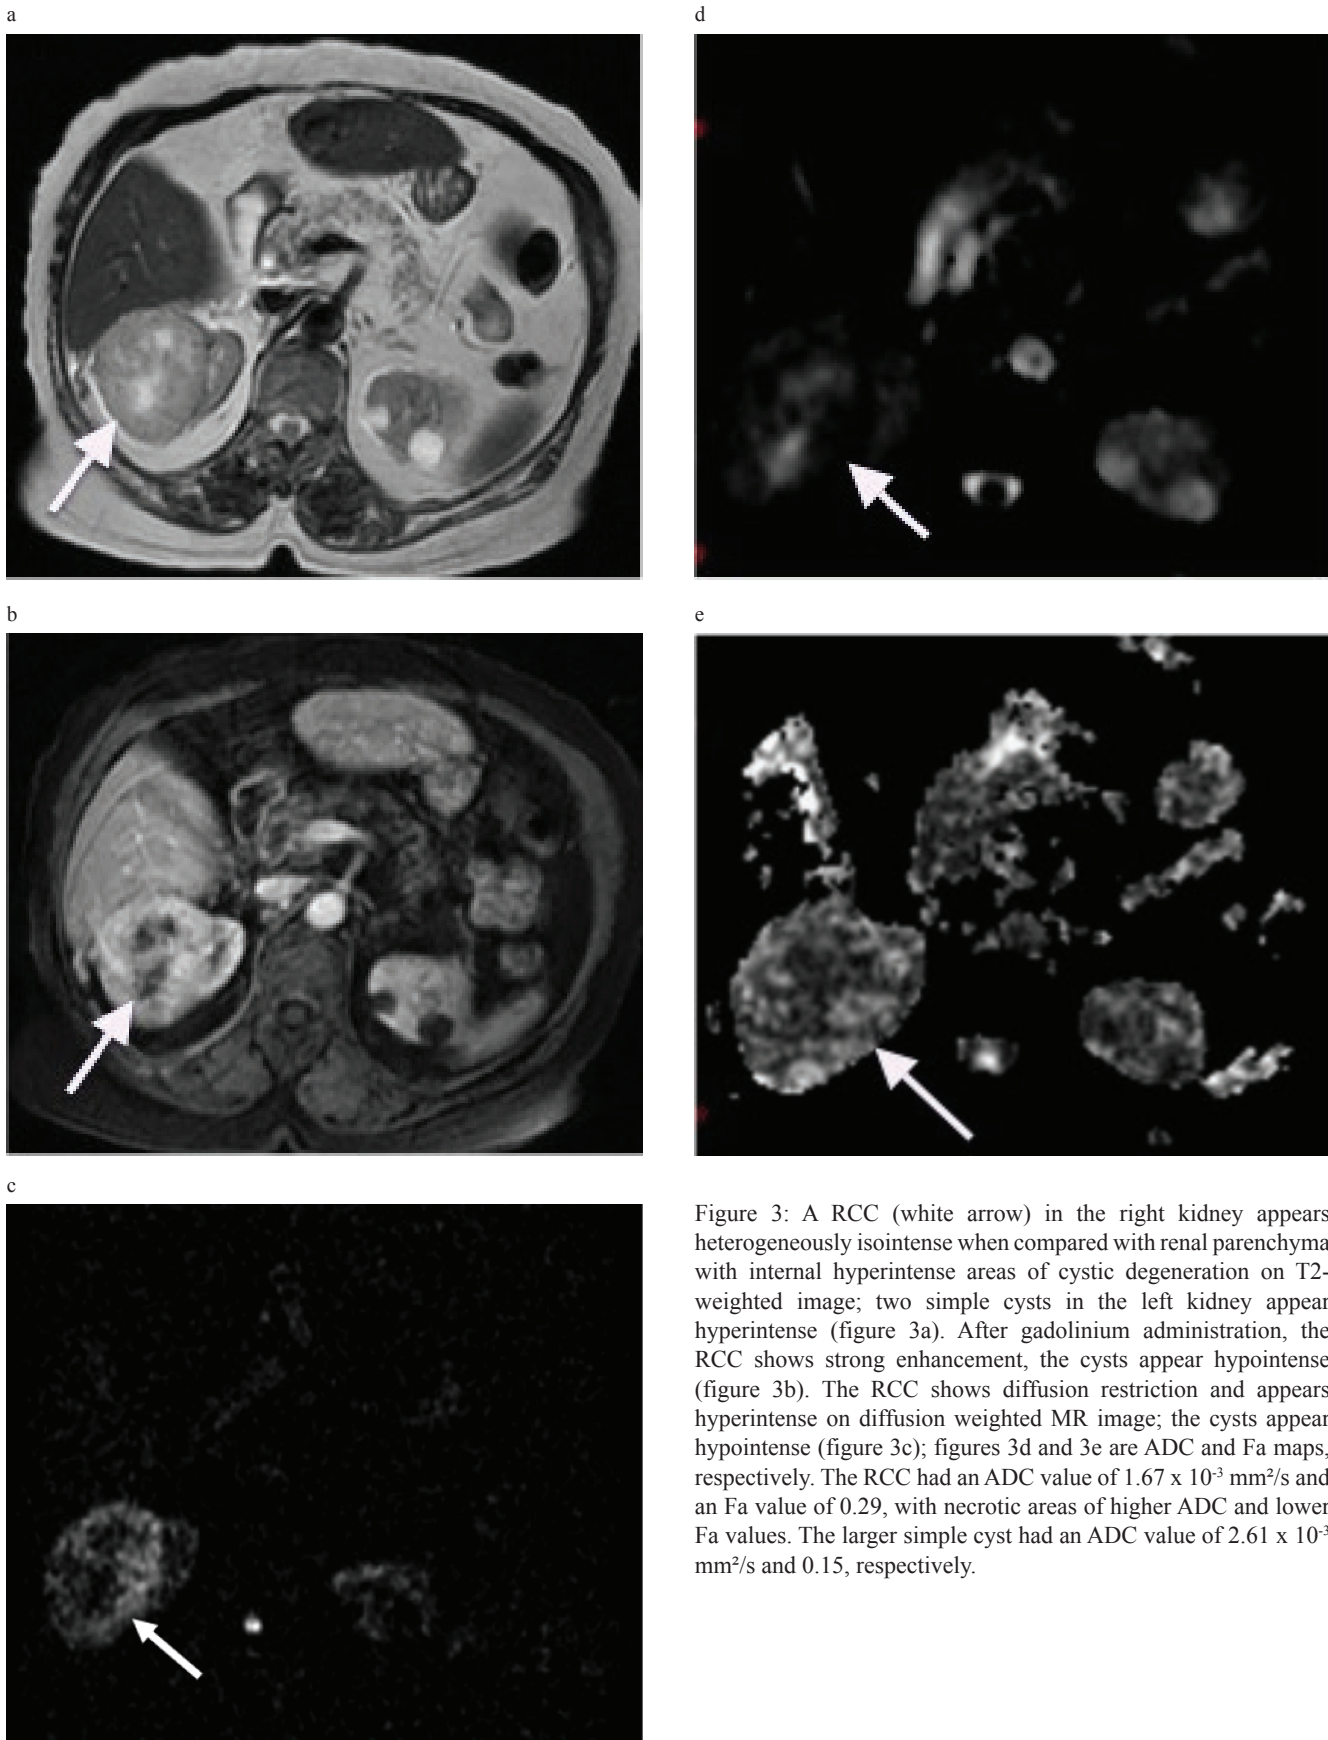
A RCC (white arrow) in the right kidney appears heterogeneously isointense when compared with renal parenchyma with internal hyperintense areas of cystic degeneration on T2-weighted image; two simple cysts in the left kidney appear hyperintense (figure 3a). After gadolinium administration, the RCC shows strong enhancement, the cysts appear hypointense (figure 3b). The RCC shows diffusion restriction and appears hyperintense on diffusion weighted MR image; the cysts appear hypointense (figure 3c); figures 3d and 3e are ADC and Fa maps, respectively. The RCC had an ADC value of $1.67 \times 10^{-3} \text{ mm}^2/\text{s}$ and an Fa value of 0.29, with necrotic areas of higher ADC and lower Fa values. The larger simple cyst had an ADC value of $2.61 \times 10^{-3} \text{ mm}^2/\text{s}$ and 0.15, respectively.
